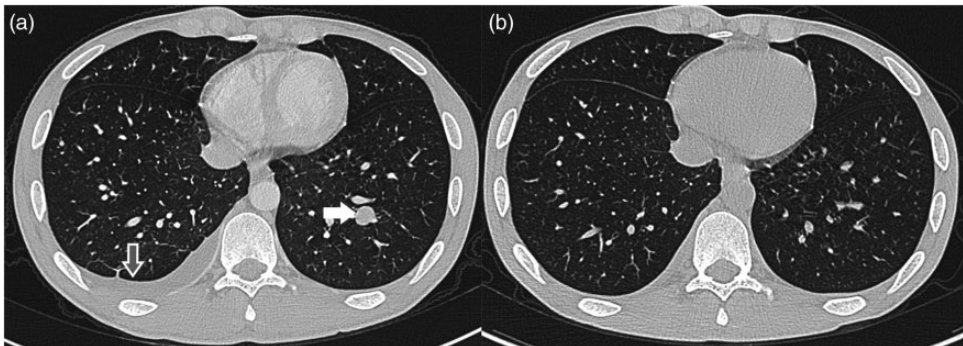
Chest computed tomography (CT) scans showing that the nodule (white arrow) in left lung and pleural effusion (gray arrow) in the right thorax (a) disappeared following treatment (b).
